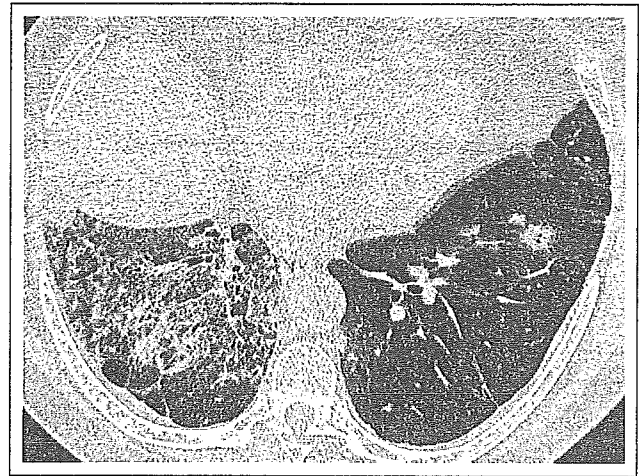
Bilateral multifocal bronchioloalveolar carcinoma with consolidative pattern. Computed tomography image shows large consolidation in the right lower lobe and nodules in the left lower lobe.
